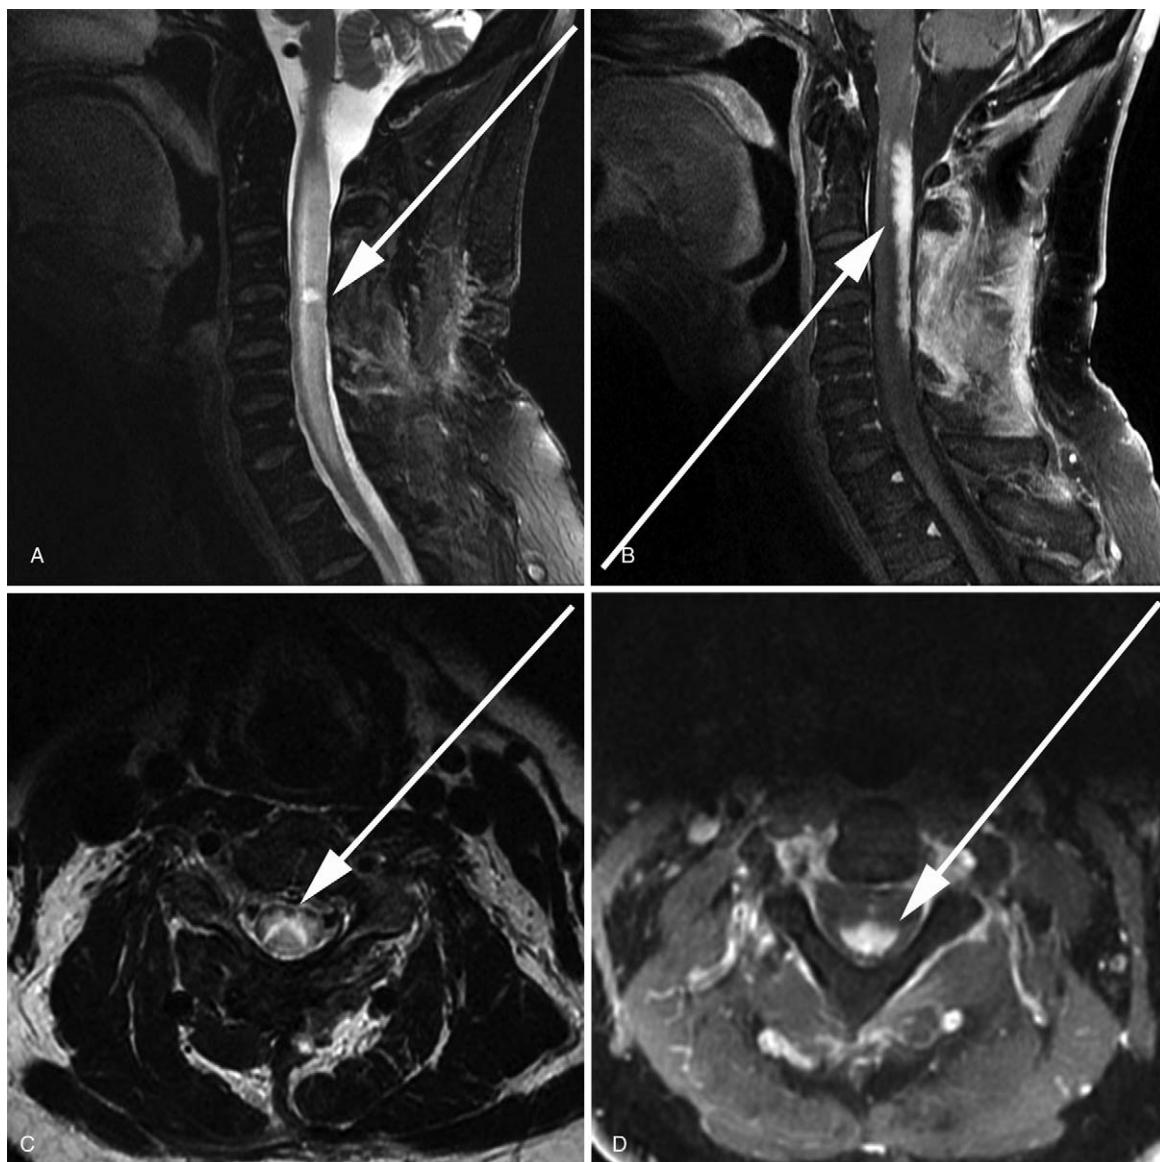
A 52-year-old man with spinal sarcoidosis who initially presented with numbness and tingling of the hands and feet. MRI of the spine revealed a long segment T2 hyperintense abnormality associated with cord dilatation along the entire cervical cord (A and C). The biopsy site is seen at the C3-4 level (A, white arrow). Postcontrast imaging (B and D) revealed an extended area of irregular bordered contrast enhancement affecting the dorsal aspect of the cord. FDG PET CT anterior projection maximal intensity projection (MIP) image of the chest (E) displays bilateral hypermetabolic hilar lymph nodes. One-hour post-FDG injection (F) PET imaging displays hypermetabolism corresponding to the area of abnormal cord enhancement with a maximum SUV of 8.0. The degree of hypermetabolism significantly increases on 5-hour postinjection imaging with a maximum SUV of 11.1 (G).
